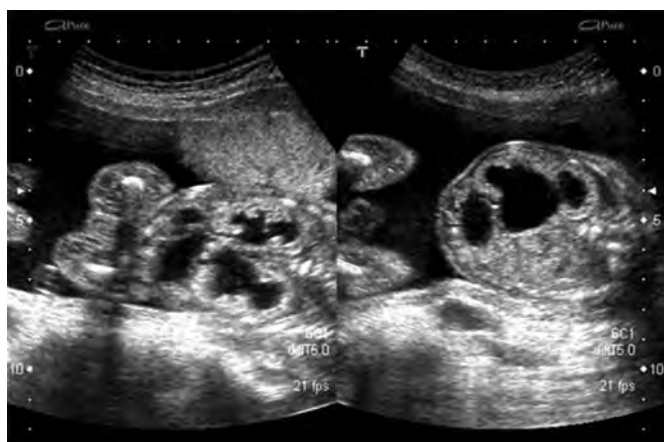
Prenatal ultrasound at 21 weeks' gestation shows bilateral hydronephrosis, tortuous left ureter, and increased echogenicity of the kidneys.
